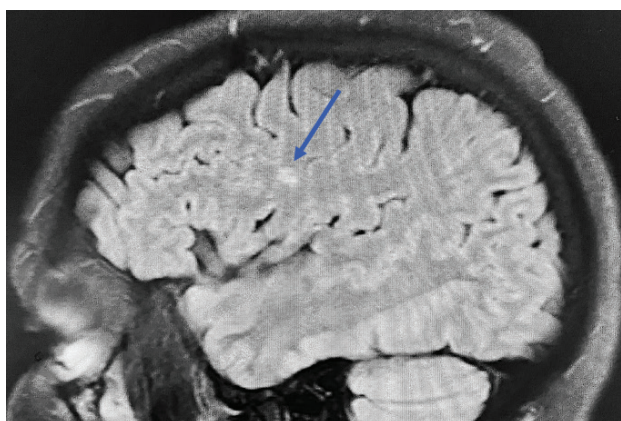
Magnetic Resonance Imaging -Sagittal image of the frontoparietal lesion on T2 Flair with the use of gadolinium contrast.
